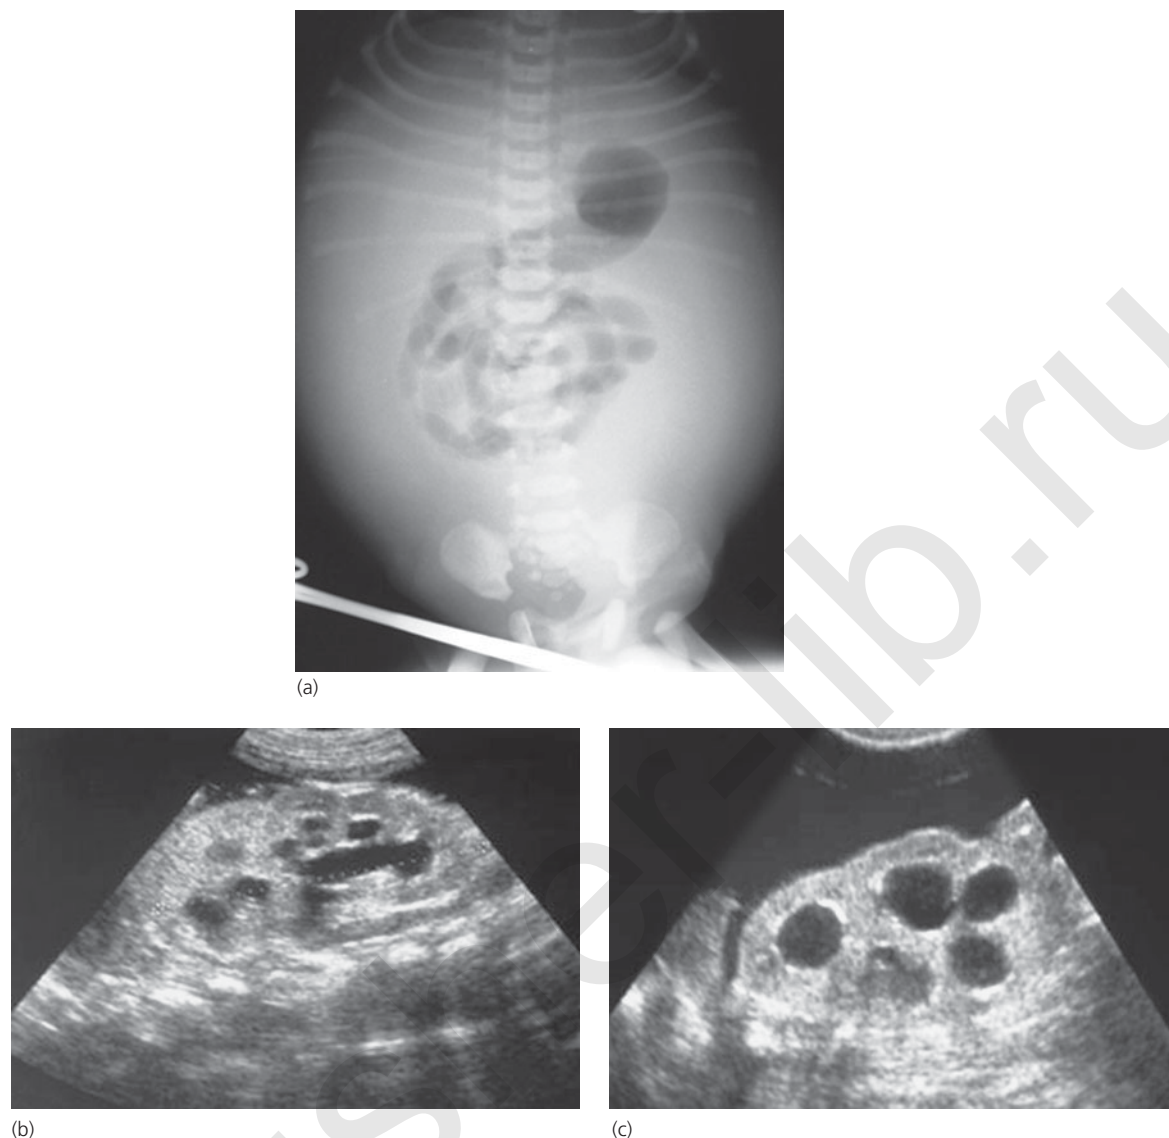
Newborn with posterior urethral valves and abdominal distension secondary to urinary ascites. (a) Plain film of abdomen showing ascites. (b,c) Renal sonogram showing bilateral hydronephrosis and urinary ascites. (d) Voiding cystourethrogram. Note dilated prostatic urethra proximal to the valve leaflets and bladder diverticulum on left side. Patient managed with upper tract drainage and transurethral incision of valve leaflets. (e,f) Renal sonogram, left and right kidneys at six months of age shows minimal hydronephrosis. At 17 years, patient had nearly normal renal appearance on ultrasound.
